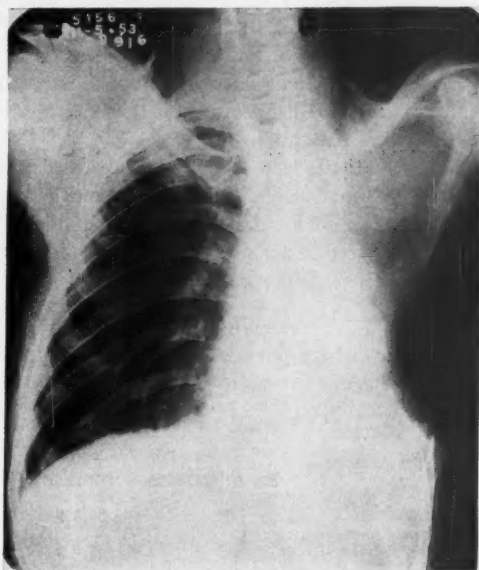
Roentgenogram made five months after left pneumonectomy and thoracoplasty
